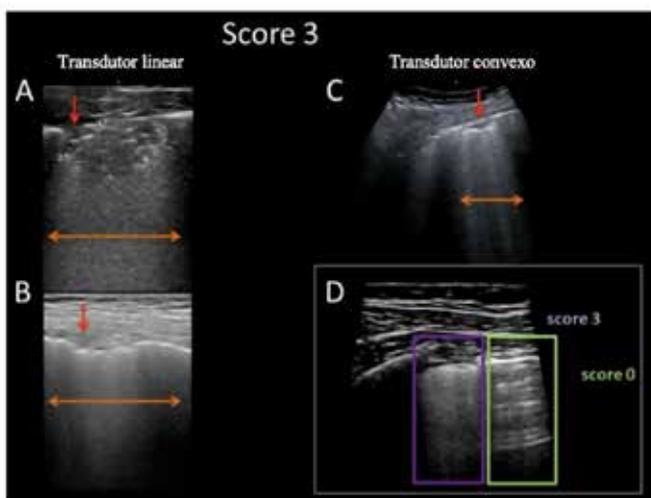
Pulmonary ultrasound images obtained with a linear (A-B) and convex (C) probe. The pleura line is severely broken. Below the point of discontinuity, large areas of consolidation (more hypoechoic areas indicated by red arrows). Hyperechogenic images between consolidation are suggestive of aerobronchograms. The “white” lung pattern, with increased echogenicity is indicated by orange arrows. This pattern is classified as Score 3. In the box at the bottom right (D), a lung image is shown where the boundary between a pattern of Score 0 (green box) and Score 3 (purple box) is clearly visible⁶.
